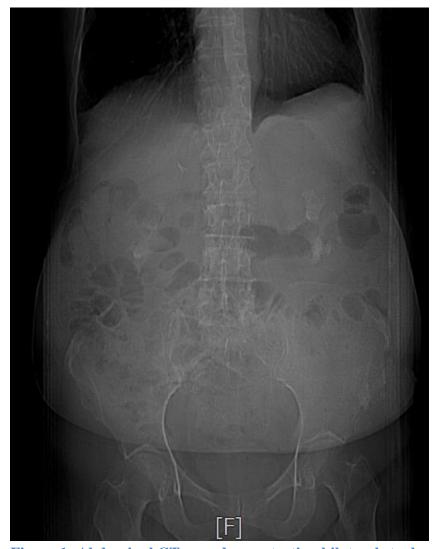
Abdominal CT scan demonstrating bilateral staghorn nephrolithiasis.
